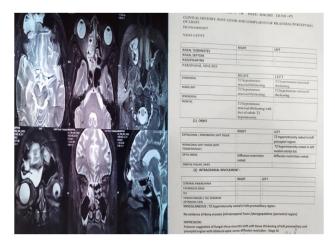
MRI paranasal sinuses with orbit report with staging of ROCM.
